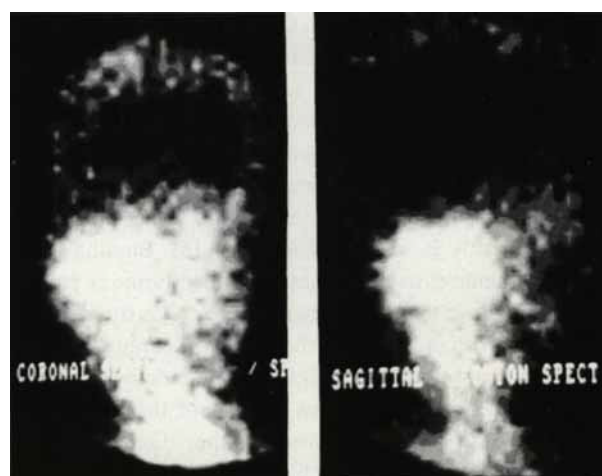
A large uptake in the right parotid region in a patient with hemangiopericytoma (visualized by SPECT) a) Coronal section. b) Sagittal section.
